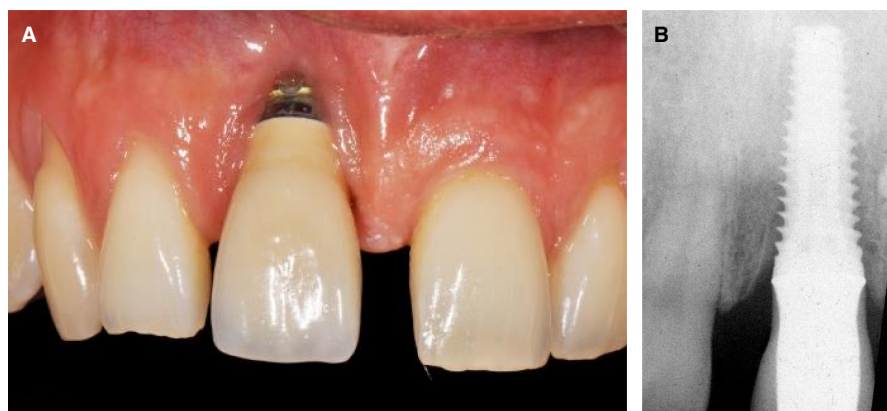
A, An implant with a shoulder diameter of 6 mm has been placed in the maxillary right central incisor site. The oversized implant has resulted in a facial malposition of the implant, and subsequent recession of the midfacial mucosa. B, The corresponding periapical radiograph of the implant
